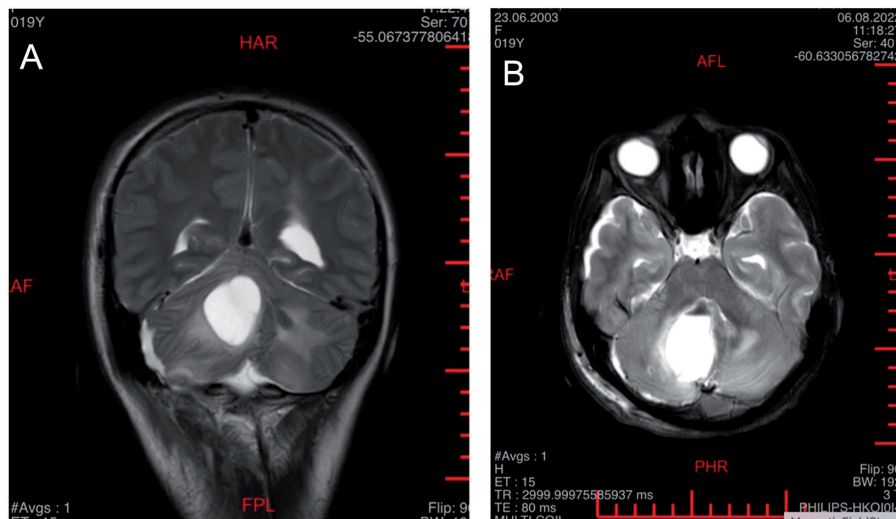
Initial cranial magnetic resonance imaging, axial (A) and coronal (B) T2-weighted turbo spin echo sequence. A massive lesion in the right cerebellar hemisphere with a 45×32 mm wall with a contrasting mural nodule.
